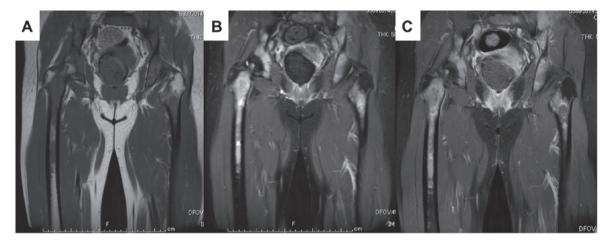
Initial magnetic resonance imaging. The mass was detected diffusely at the bilateral femur and iliac. (A) T1-weighted image; (B) T2-weighted image; (C) contrast-enhanced T1-weighted image.
